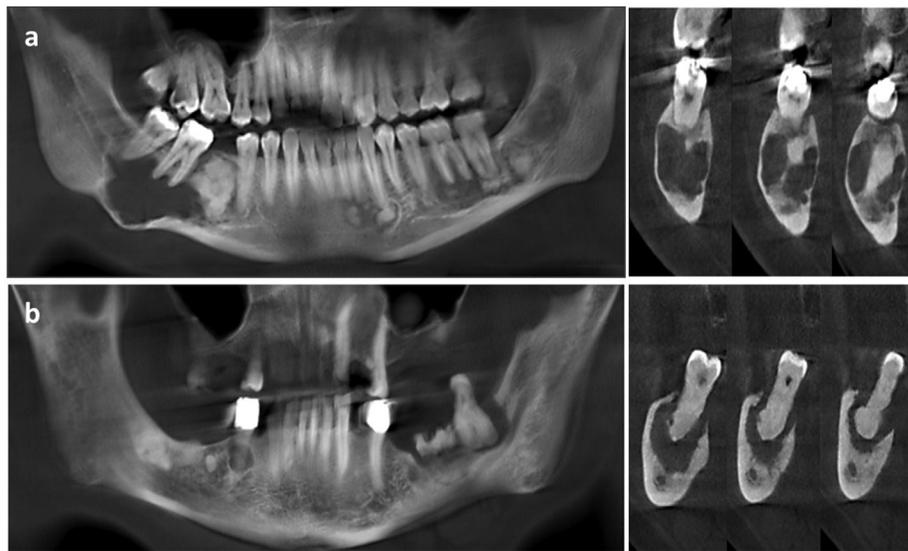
Panoramic reconstruction and cross-sectional cone beam computed tomography images of two different florid cemento-osseous dysplasia cases with a. cystic lesion exhibiting a well-defined hypodense area with cortical involvement and b. inflammatory lesion exhibiting hypodense area with a hyperdense area resembling bone sequestration and also hypercementosis.
